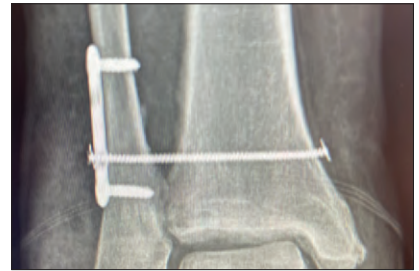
One-week post-op X-ray
